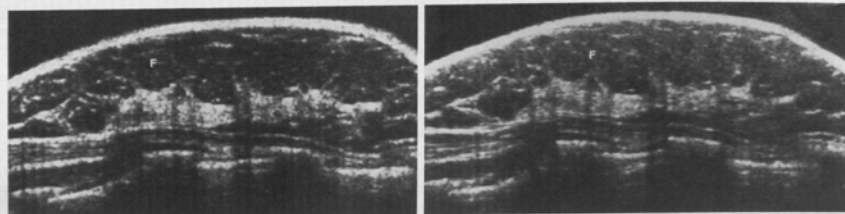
Longitudinal 4-MHz (a) and 7.5-MHz PVDF (b) sonograms of the lateral aspect of the right breast in a healthy woman. Note the overall increased echogenicity of the fat (F) on the 7.5-MHz scan, with excellent differentiation between fat and fibroglandular tissue. The penetration of this "B-cup" breast is equal with the two transducers.
